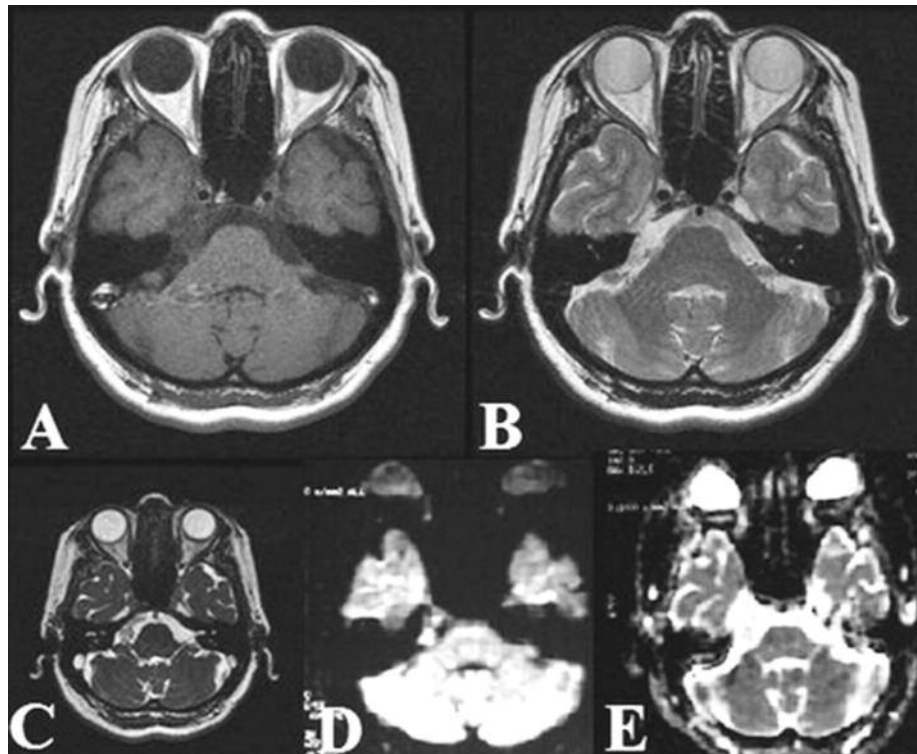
Epidermoid tumor located at right anterior CPA region. A: Axial T1 WI shows a hypointense lesion; B: Axial T2 WI shows a hyperintense lesion; C: FIESTA: demonstrates slightly hyperintense lesion D: DWI demonstrates diffusion restriction; E: ADC map shows a isointense lesion.
